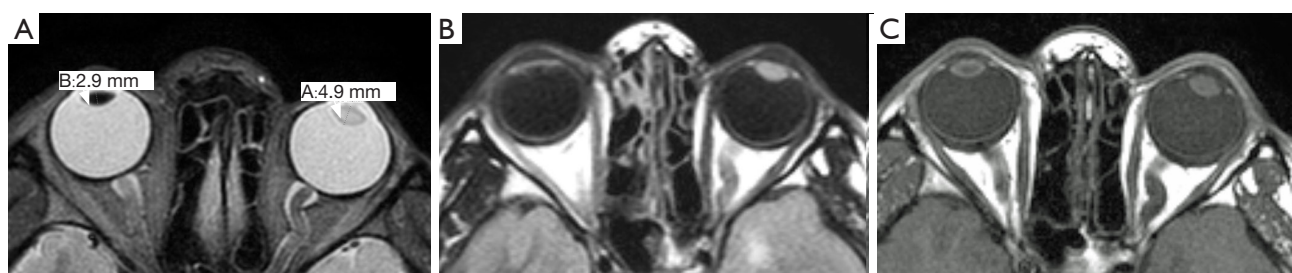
The patient (case 1) has a history of radiation-induced left cataract. The MRI obtained approximately 3 years after radiation therapy demonstrates high signal and thickening of the left lens on the axial STIR (A) and T2-weighted FLAIR (B) sequences. There is also mild high T1 signal within the central portion of the left lens (C). MRI, magnetic resonance imaging; STIR, short tau inversion recovery; FLAIR, fluid attenuated inversion recovery.
